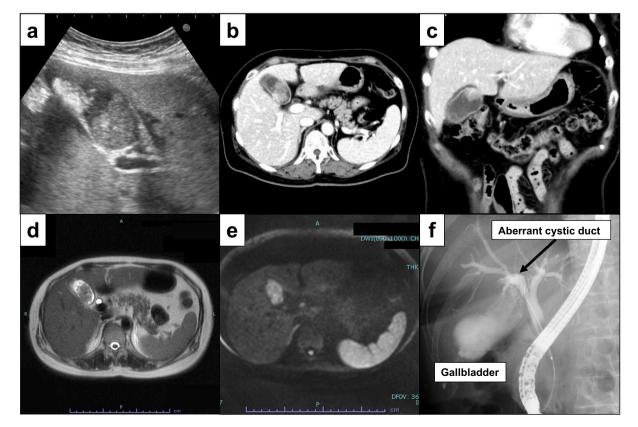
a: US, b: axial CT, c: coronal CT, d: MRI, e: DW-MRI, f: ERC.
